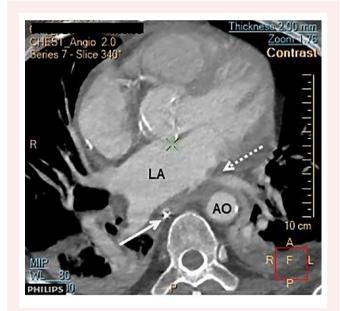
Axial imaging of a non-gated chest computed tomography angiogram. The computed tomography shows left inferior pulmonary vein stenosis (interrupted arrow), probably as consequence of the recent cryoablation procedure, and a small amount of pericardial fluid. The continuous arrow indicates the location of the nasogastric tube inserted into the oesophagus. AO, descending aorta; LA, left atrium.
